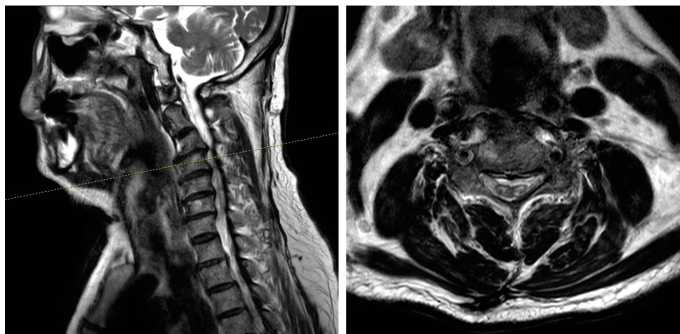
Patient's cervical spine magnetic resonance imaging(T2) (Sagittal, Axial at C4 body level) on August 18, 2019.
